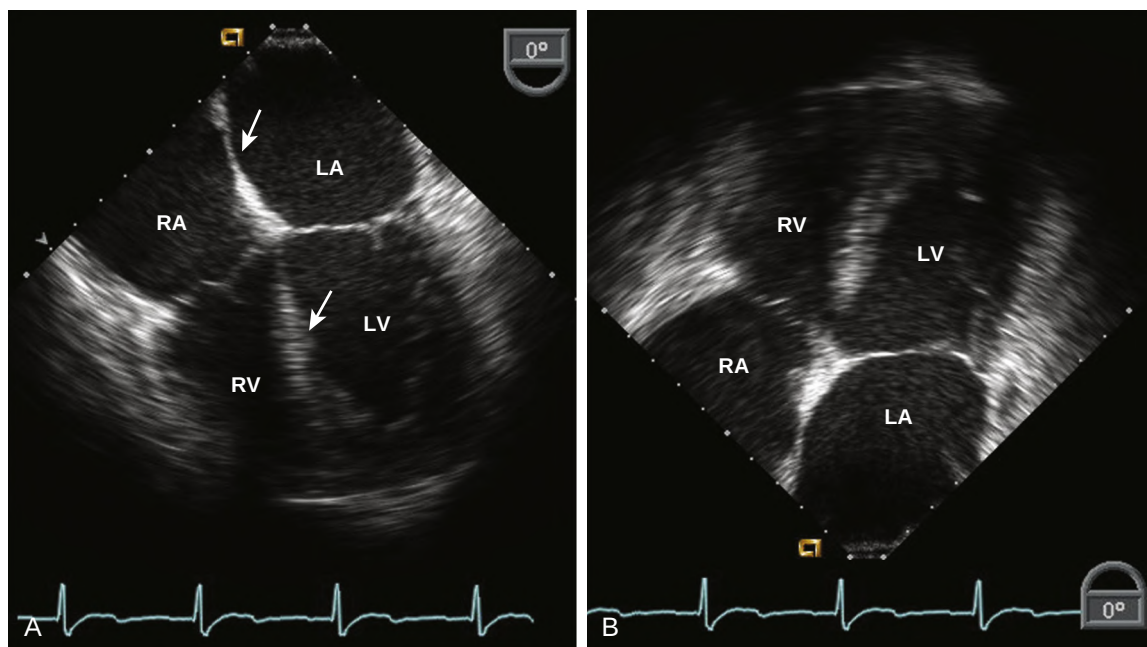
Lateral resolution with ultrasound decreases with the distance of the reflector from the transducer. (A) In this TEE image oriented with the origin of the ultrasound signal at the top of the image, thin structures close to the transducer, such as the atrial septum (*upper arrow*), appear as a dot because lateral resolution is optimal at this depth. Reflections from more distant structures, such as the ventricular septum (*lower arrow*), appear as a broad line due to poor lateral resolution. (B) When the image is oriented with the transducer at the bottom of the image, the effects of depth on lateral resolution are more visually apparent. The standard orientation for echocardiography with the transducer as the top of the image is based on considerations of ultrasound physics, not on cardiac anatomy.
